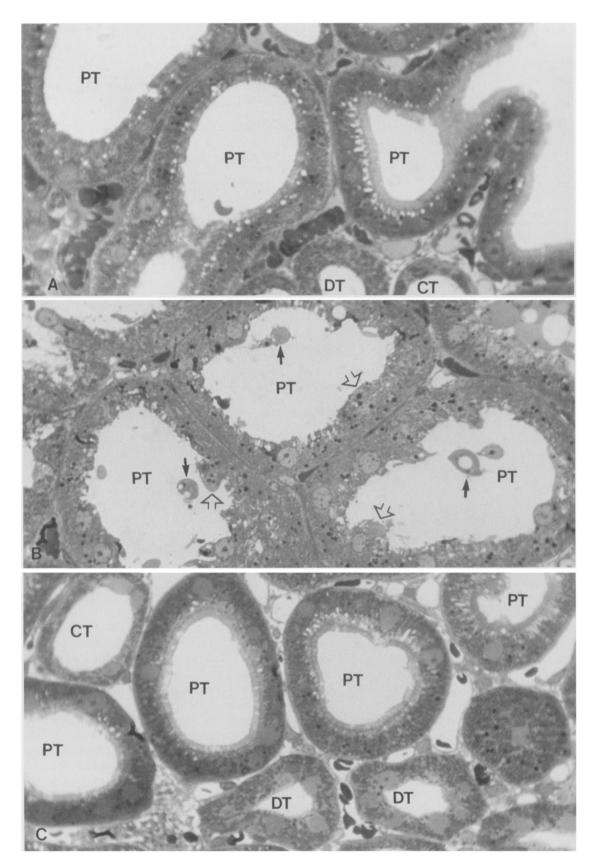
Effect of mild ischemia (15 min) and reperfusion (2 hr) on proximal tubule morphology. (A) In vivo perfusion-fixed control proximal tubules showing normal cellular morphology $(540\times)$. (B) In vivo perfusion-fixed proximal tubules following 15 min of ischemia induced by renal artery clamping. Note protrusion of the cytoplasm into the lumen (open arrows) and blebbing of cytoplasmic contents into the lumen (solid arrows) $(540\times)$. (C) In vivo perfusion-fixed proximal tubules following 15 min of ischemia and 2 hr of reperfusion. Cellular morphology has returned to normal. $(540\times)$. Proximal tubules (PT) distal tubules (DT) and cortical collecting tubules (CT) are labeled
